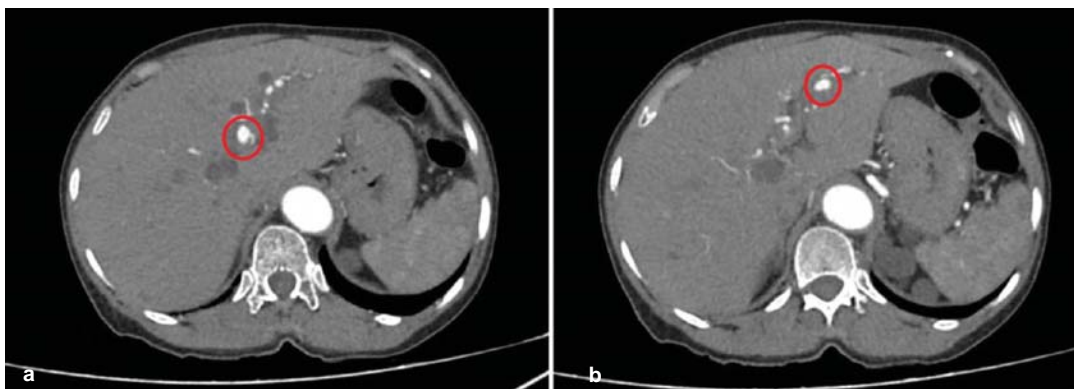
Axial computed tomography images showing two small aneurysms of the branches of hepatic artery (red circles in a and b)
